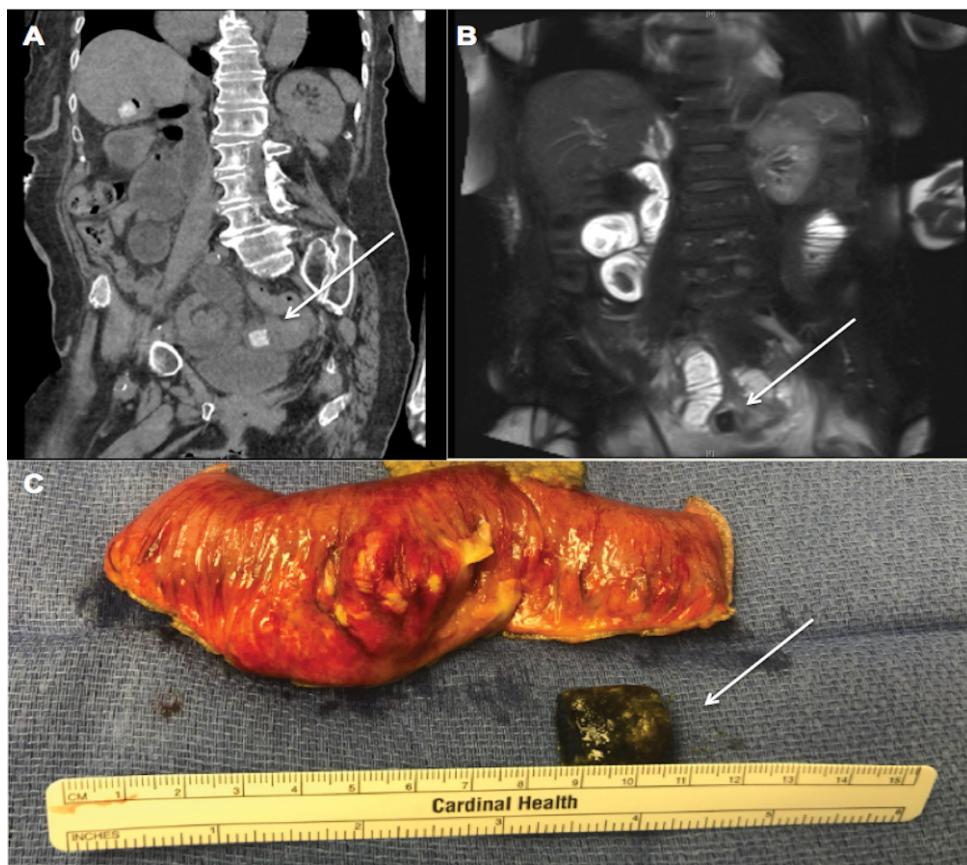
CT scan (A) MRI; (B) of the abdomen and pelvis demonstrates intra luminal gallstone in the distal jejunum with resultant small bowel obstruction. At surgery, a 2 cm obstructing gallstone was noted in the distal jejunum; (C) small bowel resection was performed secondary to perforation at the site of stone impaction.
